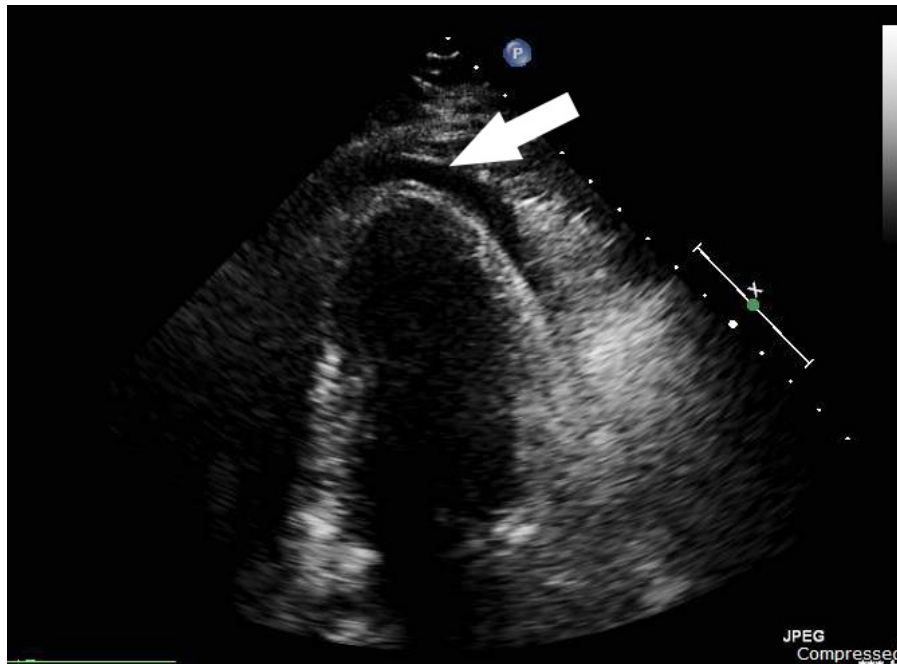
Emergent transthoracic echocardiogram performed in the cardiac catheterization lab prior to pericardiocentesis: two-chamber apical view showing a small pericardial effusion (arrow). See the supplemental file “Video2.mp4” for a video of this ultrasound.
